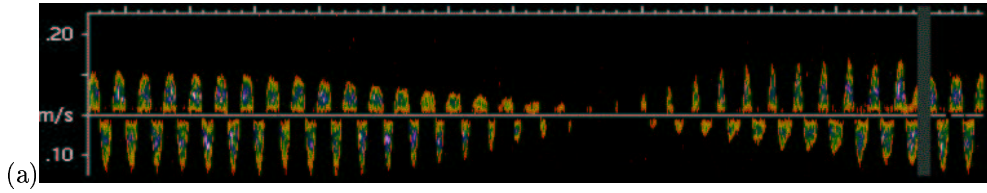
A flow waveform in an arterio-arterial anastomosis obtained using a Doppler ultrasound flow probe.
